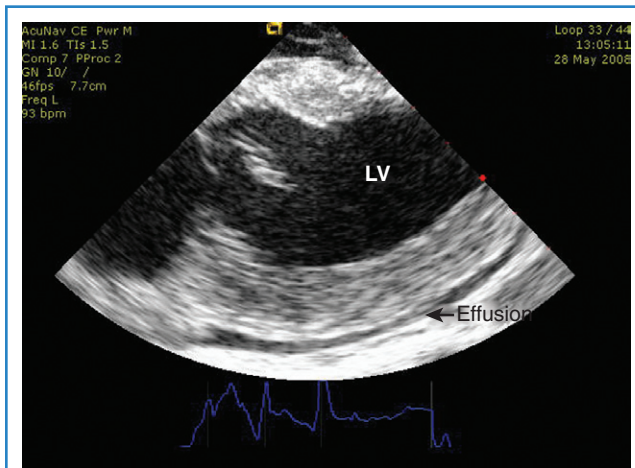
Intracardiac echocardiography (ICE) image of the left ventricle (LV) in longitudinal view, demonstrating a pericardial effusion that appears as a hypoechoic region outside the ventricular myocardium (arrow). This image is obtained by retroflexion of the ICE catheter and positioning the catheter across the tricuspid valve and within the right ventricle.
